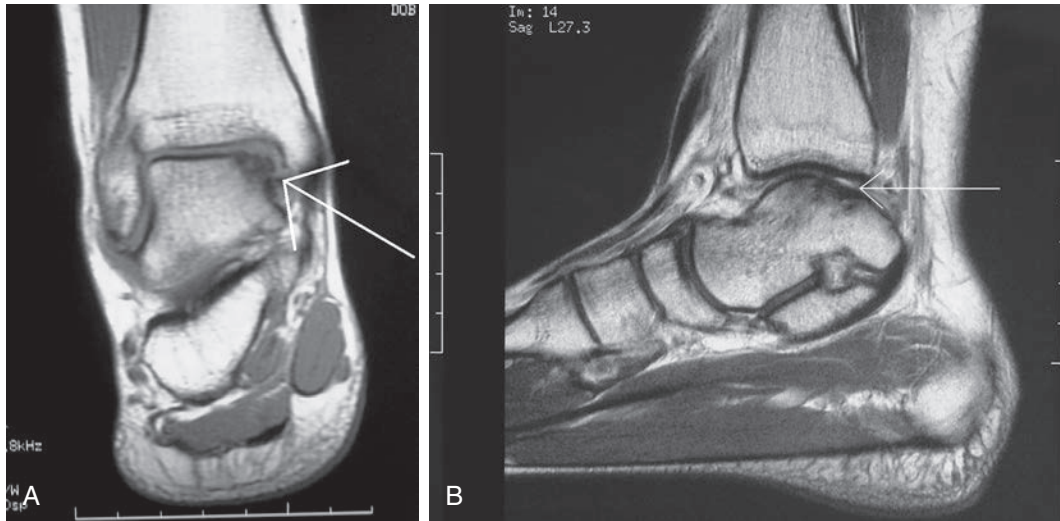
Osteochondral Defect of the Talus in Dancers. Magnetic resonance image demonstrating a posteromedial talar dome lesion in (A) coronal and (B) sagittal T1 views.
